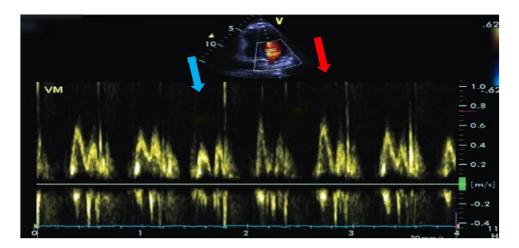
Doppler echocardiography showing mitral inflow velocity with respiratory variation; Inspiration (blue arrow), Expiration (red arrow).
